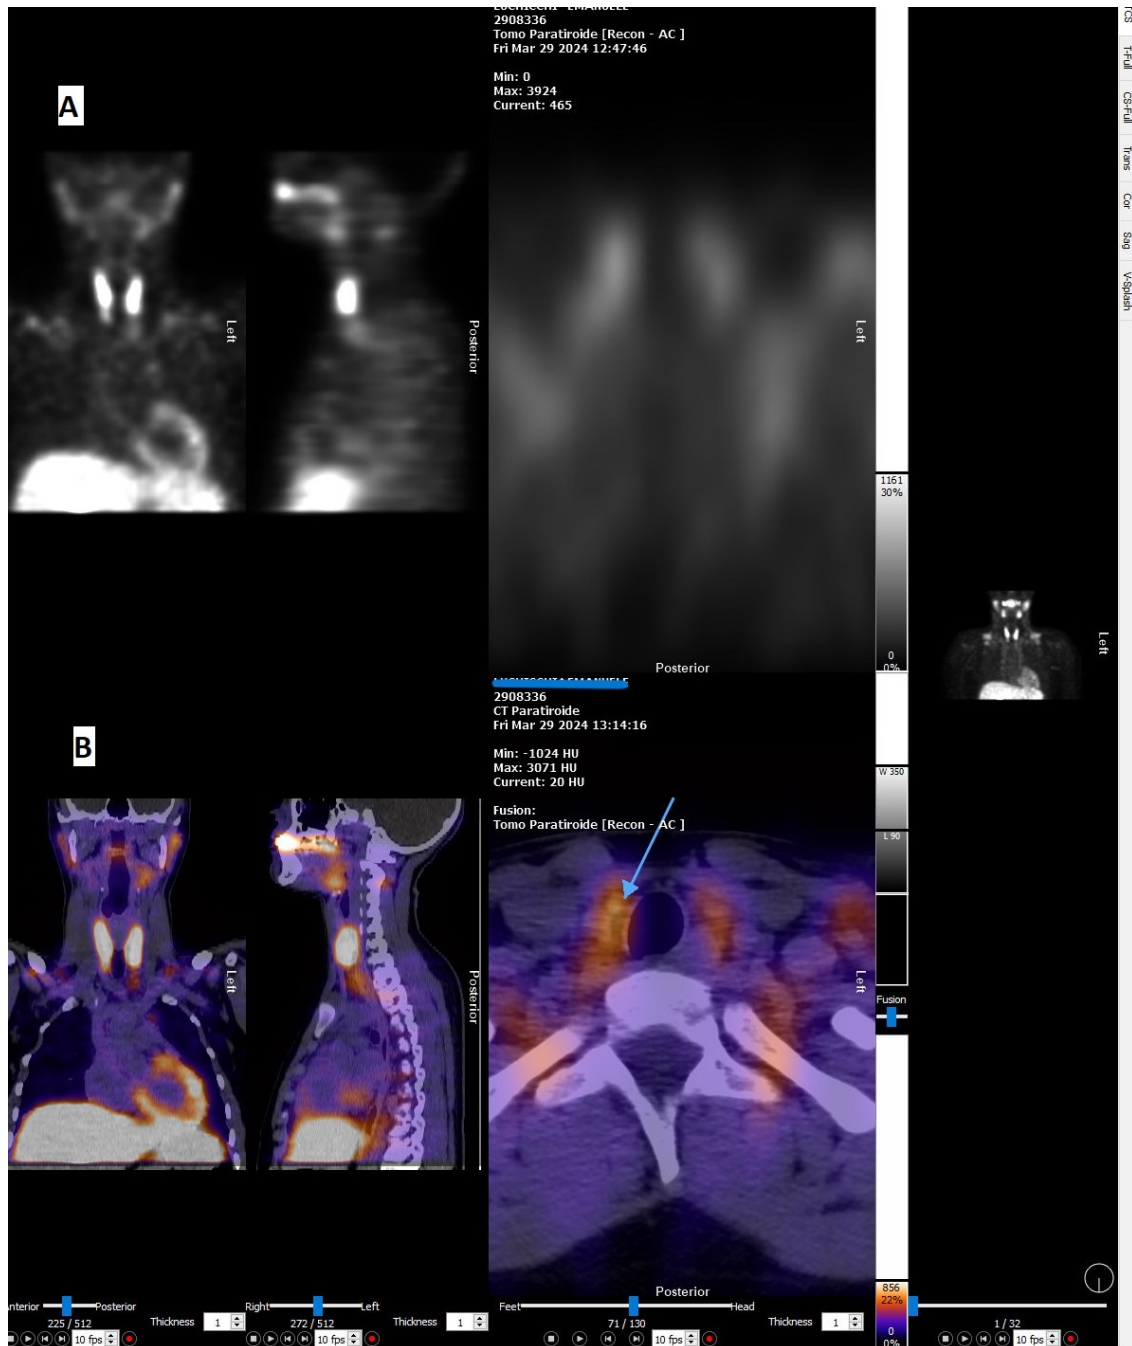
Case 6: SPECT/CT images with low-dose CT show a suspected area corresponding to a nodulation located posteriorly of the right thyroid lobe (the blue arrow indicates the location of the suspicious nodular area). (A) SPECT images. (B) SPECT/CT fused images.
